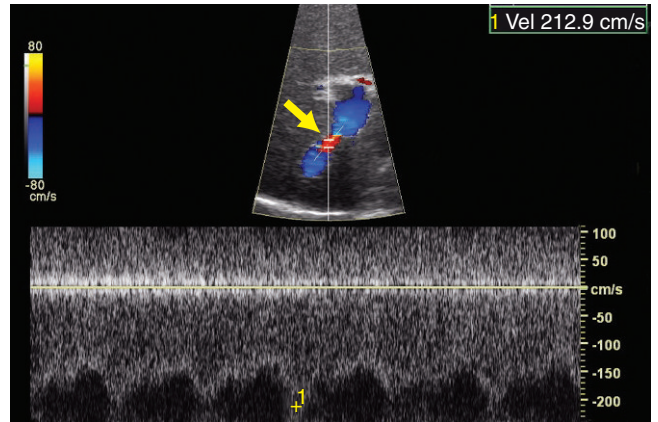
The duplex and color Doppler image shows an elevated velocity of 213 cm/sec in the stent graft at a site of focal aliasing (arrow) indicating a stenosis. Normal stent graft velocities range between 90 and 190 cm per second.
